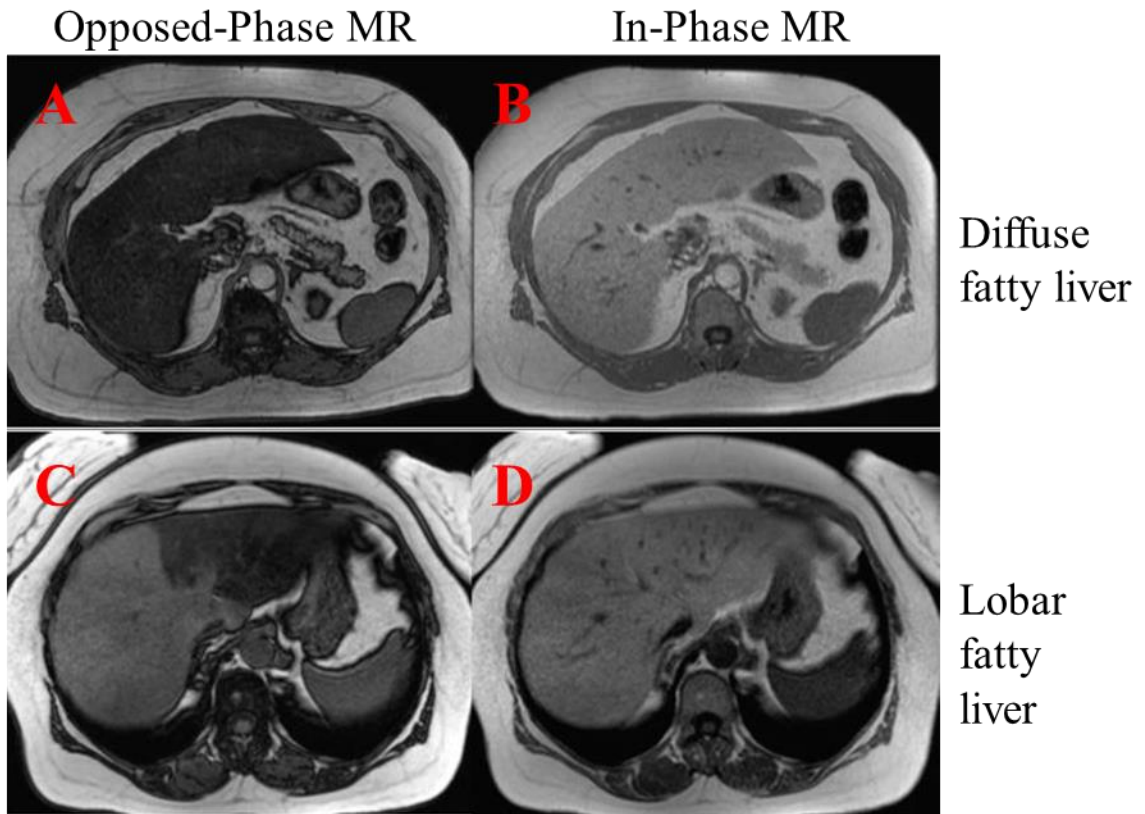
Opposed phase and In-phase MRI images show regions of the liver with large lipid deposits. The liver in panel A appears uniformly darker than the liver in panel B. The dark areas (the entire liver in this case) are the lipid deposits. In panel C, a large region of the liver is darkened, showing a lobe-specific regional deposition of lipid droplets.
